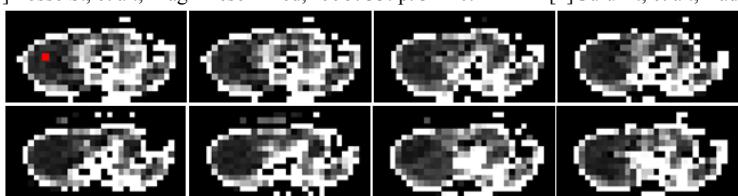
(a) Liver ROI localization in T1-weighted gradient echo imaging.
